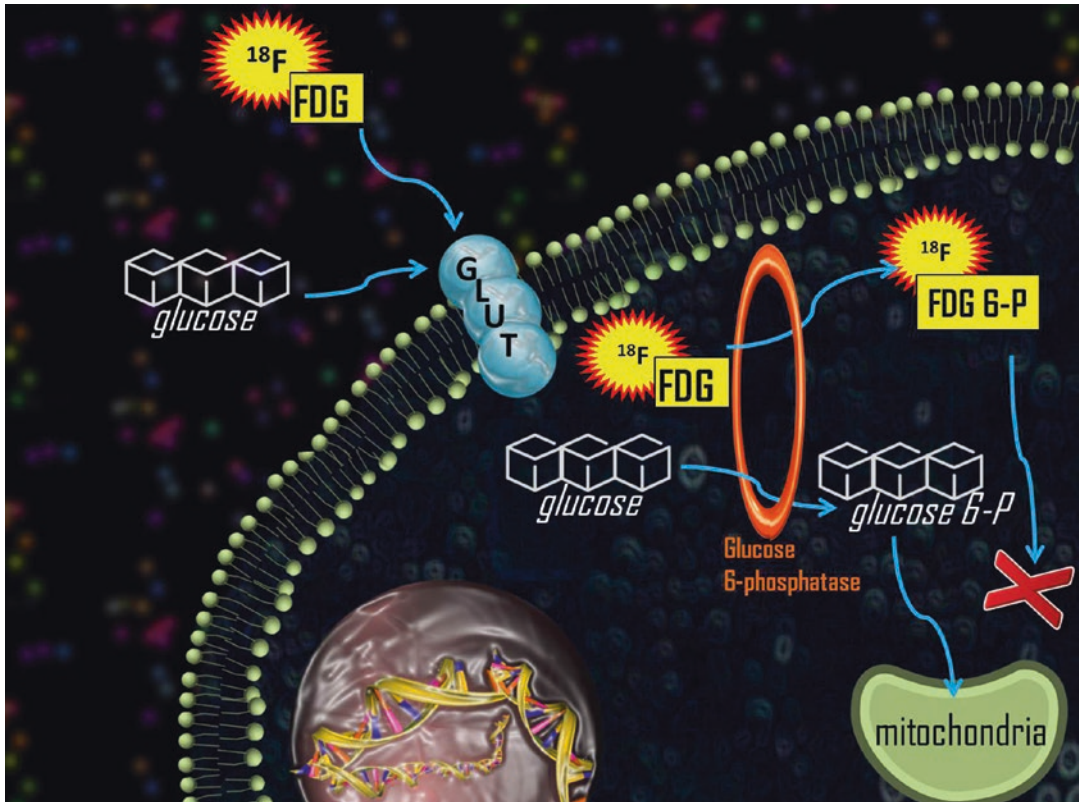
Being an analog of glucose, the ^{18}F -FDG is internalized in cells and phosphorylated
